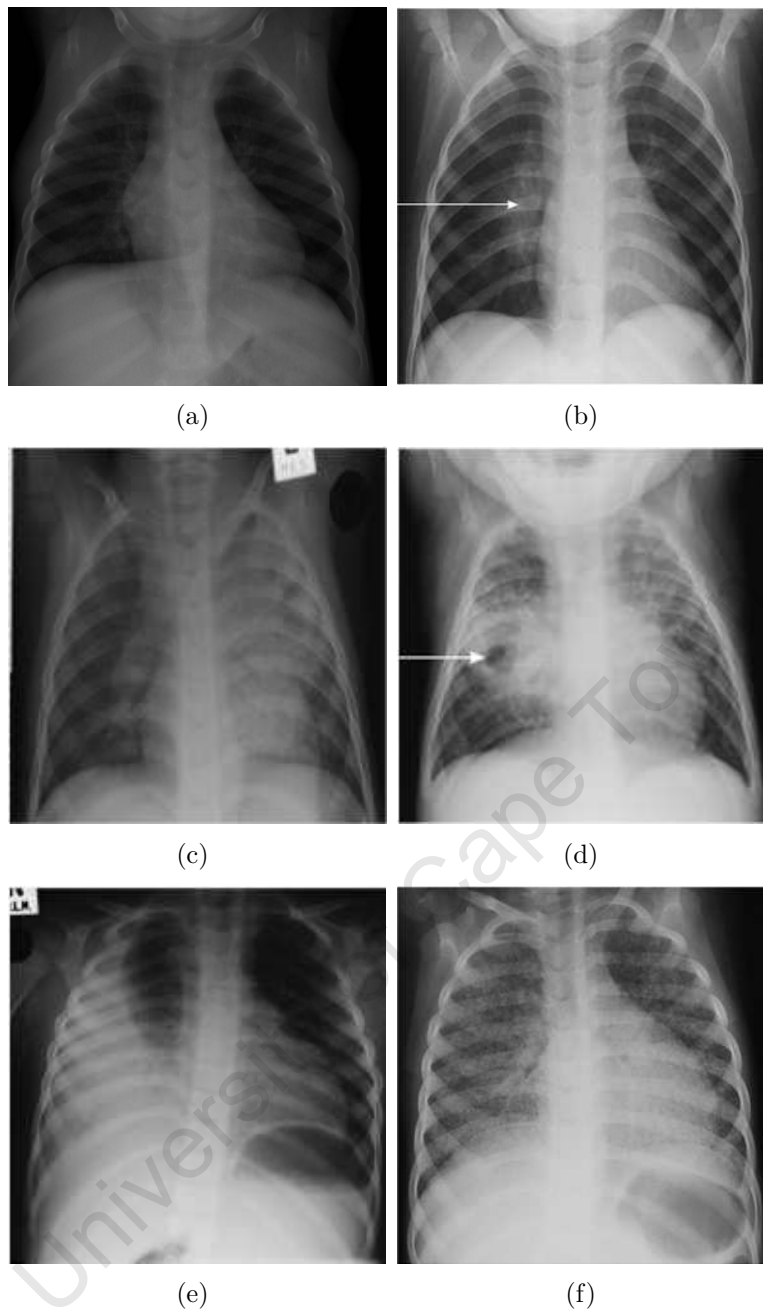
(a) A completely healthy chest X-ray. (b) Typical hilar lymph gland enlargement in the right lung field. (c) Extensive infiltration (consolidation) of the left lung field; note the brighter appearance in comparison with the right lung field. (d) A cavity in the right middle lobe. (e) Extensive pleural effusion in the right lung field. (f) Microcondular infiltrates diffusely distributed throughout both lung fields (Miliary TB). Abnormal images obtained from [18].
